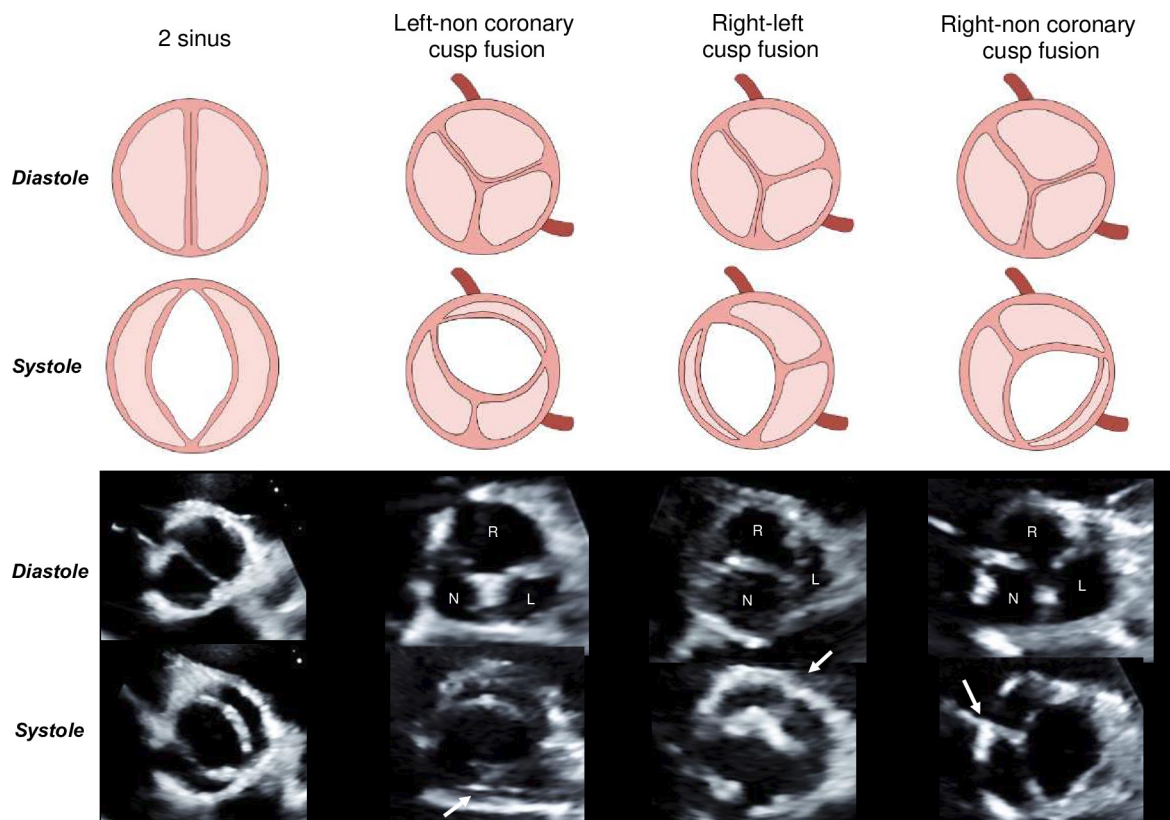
Bicuspid leaflet fusion subtypes. Determination of bicuspid aortic valve leaflet fusion subtypes using parasternal short axis echocardiographic view in systole and diastole based on the Michelena *et al.* classification. The white arrow indicates the raphe. N, non-coronary leaflet; L, left coronary leaflet; R, right coronary leaflet.
